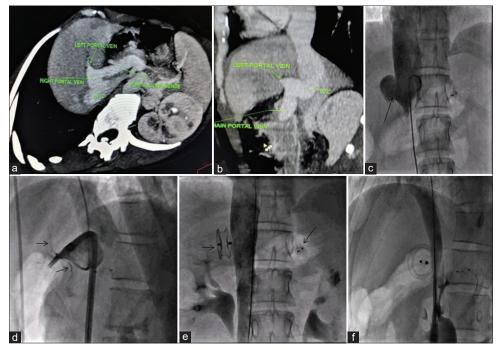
(a) CT axial oblique view depicting the point of communication between the right branch of PoV and IVC immediately after portal vein bifurcation. The labels on the figure from top right and clockwise indicate the left portal vein, portal confluence, IVC and right portal vein respectively, (b) CT coronal oblique view depicting the CPS. The labels on the figure from top right and clockwise indicate the left portal vein, IVC and the main portal vein, (c) Pigtail angiogram of IVC showing the CPS (arrow) in AP view, (d) Cook sheath with end-hole catheter introduced deep into the left portal vein showing hypoplastic portal vein radicles in steep LAO view. Note the JR diagnostic catheter introduced into the CPS from the IJV, (e) IVC angiogram in AP view showing no residual shunt after placement of 20-mm muscular VSD occluder (arrow) in the CPS. Note the ADO-II device in the splenic artery in the background (arrow), (f) IVC angiogram in lateral view showing a well-positioned muscular VSD occluder (en face view) and no residual shunt. CT: computerized tomography, PoV: portal vein, IVC: inferior vena cava, CPS: congenital portosystemic shunt, AP: Anteroposterior, LAO: Left anterior oblique, JR: Judkins right, IJV: Internal jugular venous, IVC: Inferior vena cava, VSD: Ventricular septal defect, ADO-II: Amplatzer Duct Occluder-II
